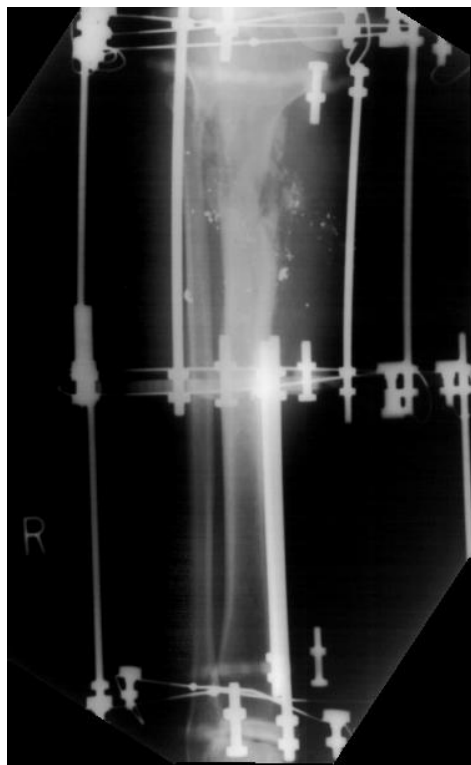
Lateral radiograph of the same fracture with Ilizarov fixator.
